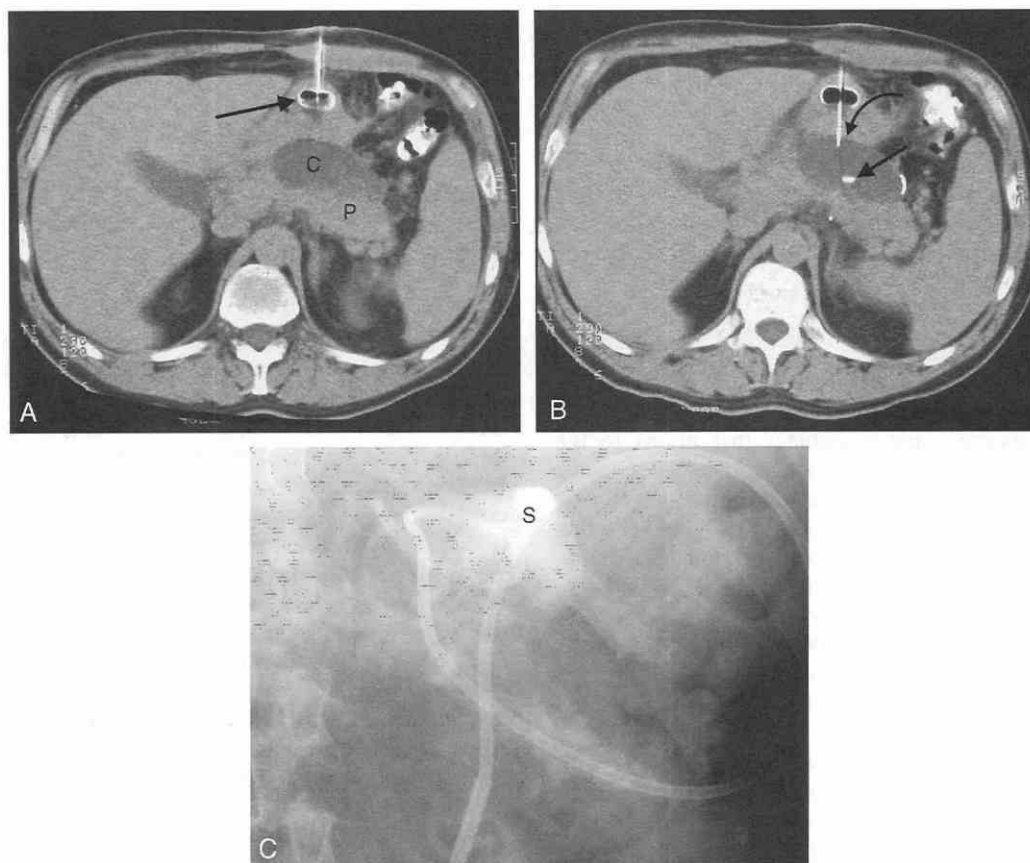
A, Scan shows pseudocyst (C) anterior to the pancreas (P). Note the percutaneous endoscopic gastrostomy (arrow) anteriorly in the stomach. B, Scan shows the needle (curved arrow) penetrating the end of the tube into the cyst, and the wire (arrow) looped in the pseudocyst. C, Radiograph shows a large tube traversing the stomach and located in pseudocyst; contrast medium defines the stomach (S).
